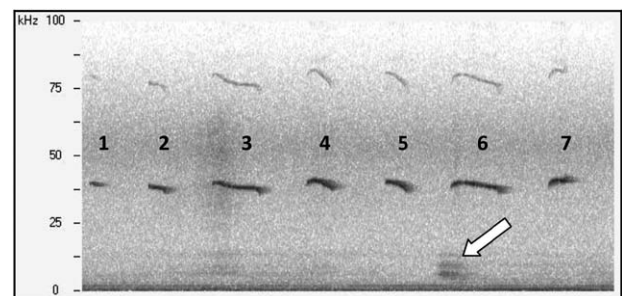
Examples of vocalizations. A 2-s snapshot taken from a sound recording made using Seawave software (Gianni Pavan, Centro Interdisciplinare di Bioacustica e Ricerche Ambientali, Pavia, Italy). Time is on the x-axis and frequency on the y-axis (0 to 100 kHz). The sonograms of seven ultrasonic vocalizations, labelled one to seven, can be seen at approximately 40 kHz. Harmonics can also be seen at approximately 80 kHz. Vocalization number 6 has a component audible to humans (below 20 kHz) and is marked with the arrow.
